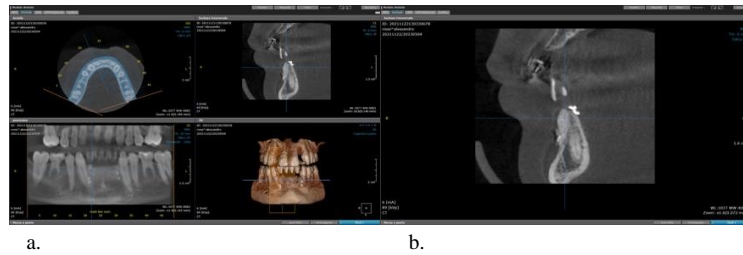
A): CBCT Image; B): the sagittal section shows evident regeneration of the horizontal dimension.*
